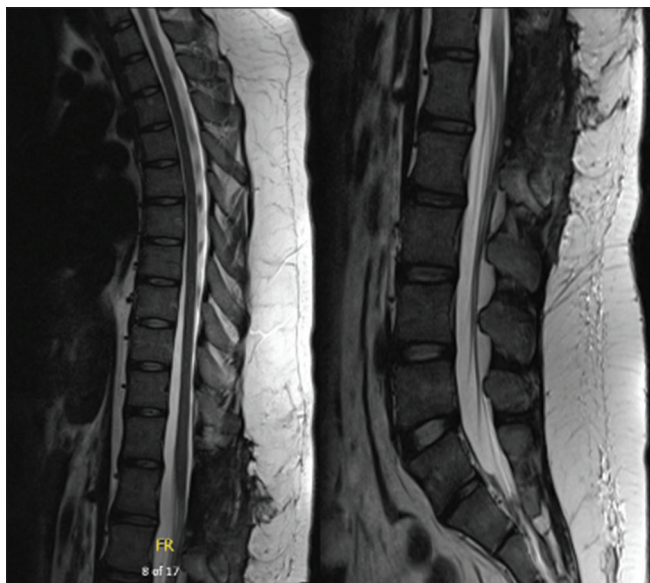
Postoperative T2-weighted midsagittal thoracic and lumbar magnetic resonance imaging.
